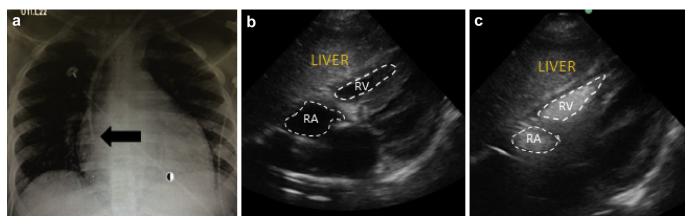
(a) Bedside chest radiograph showing the adequate positioning of the hemodialysis catheter in the superior vena cava (black arrow) after insertion in the left internal jugular vein. (b) Ultrasound subxiphoid view showing right atrium (RA) and ventricle (RV) before the administration of microbubbles through the distal lumen of the catheter. (c) Ultrasound subxiphoid view showing the irruption of microbubbles in the RA and RV 1.5 seconds after their flush through the distal lumen of the catheter. Dynamic views can be visualized in Figure 3.
